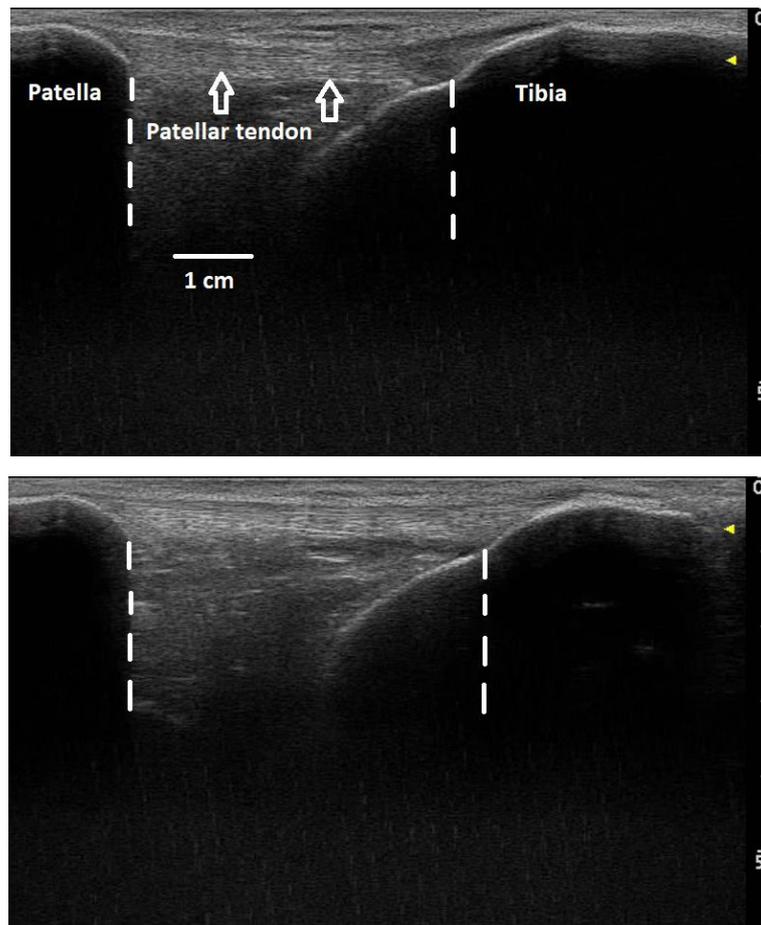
Ultrasound scans showing the patellar tendon at rest (top) and stretched (bottom) during quadriceps muscle electrical stimulation (current intensity=45 mA)
